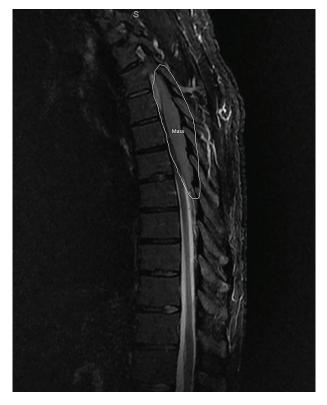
MRI spine lateral view showing the mass in the thoracic spine.
